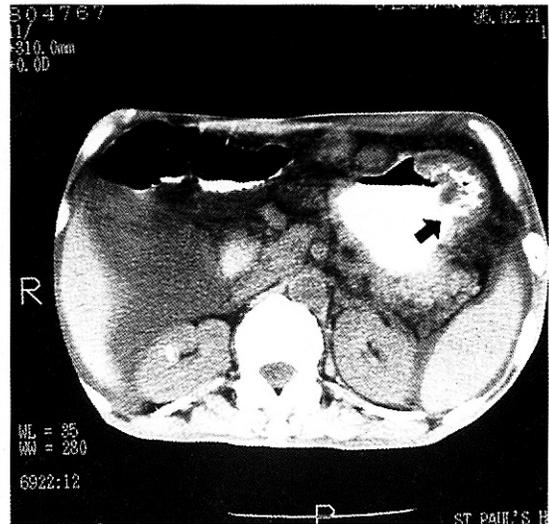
Unenhanced CT scan showing fistulous tract (arrow) between the gastric antrum and the proximal portion of descending colon, and irregularly thickened gastric wall, perigastric lymphadenopathy and ascites.
